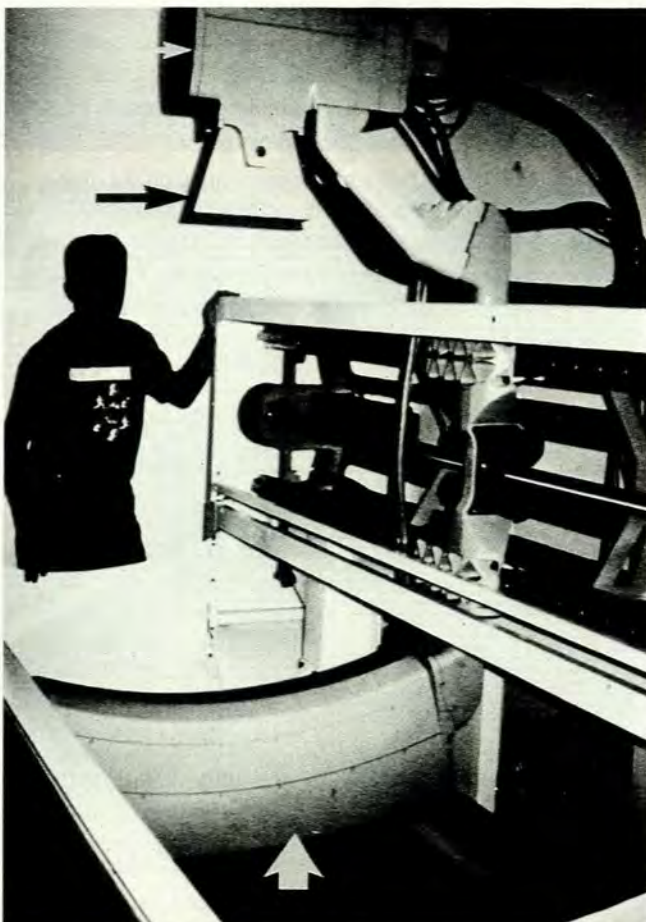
Unit after removal of patient bed and machine housing showing detector array (broad arrow), X-ray tube housing (small white arrow) and collimator (black arrow).
